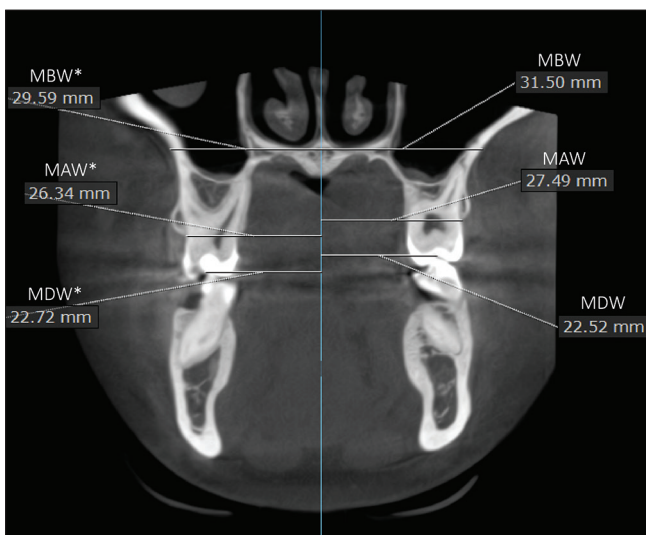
CBCT coronal section at the level of the maxillary first molars. MBW: Maxillary first molar basal width. MAW: Maxillary first molar alveolar width. MDW: Maxillary dental width. * Indicating the non-impacted side. Vertical line = the midline, a perpendicular line from ANS
